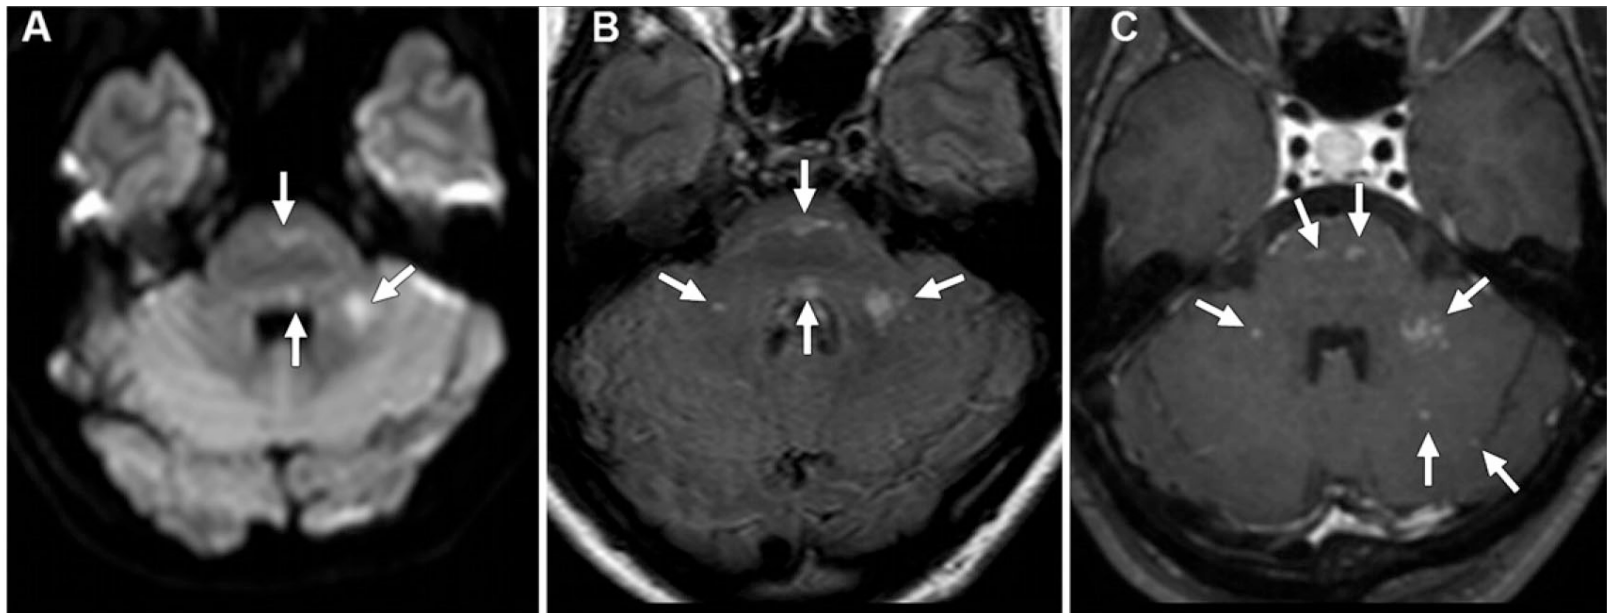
Axial MR images in 28-year-old patient with asymptomatic NTZ PML involving left middle cerebellar peduncle and brainstem. Hyperintense punctate lesions are visible on both, *A*, DW and, *B*, FLAIR images (arrows). *C*, On T1-weighted postcontrast image, additional enhanced punctate lesions are detected in cerebellum and brainstem (arrows).
